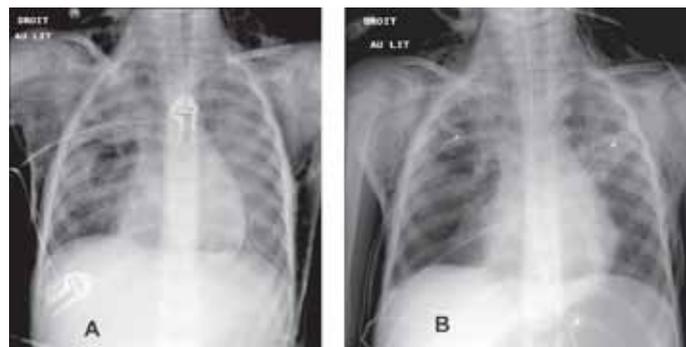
Chest radiographs of case 2. (A) The left X-ray shows bilateral infiltrates associated with diffuse subcutaneous emphysema. (B) Twenty-four hours after the onset of NAVA, the subcutaneous emphysema started to decline. Abbreviations: NAVA, neurally adjusted ventilatory assist.
